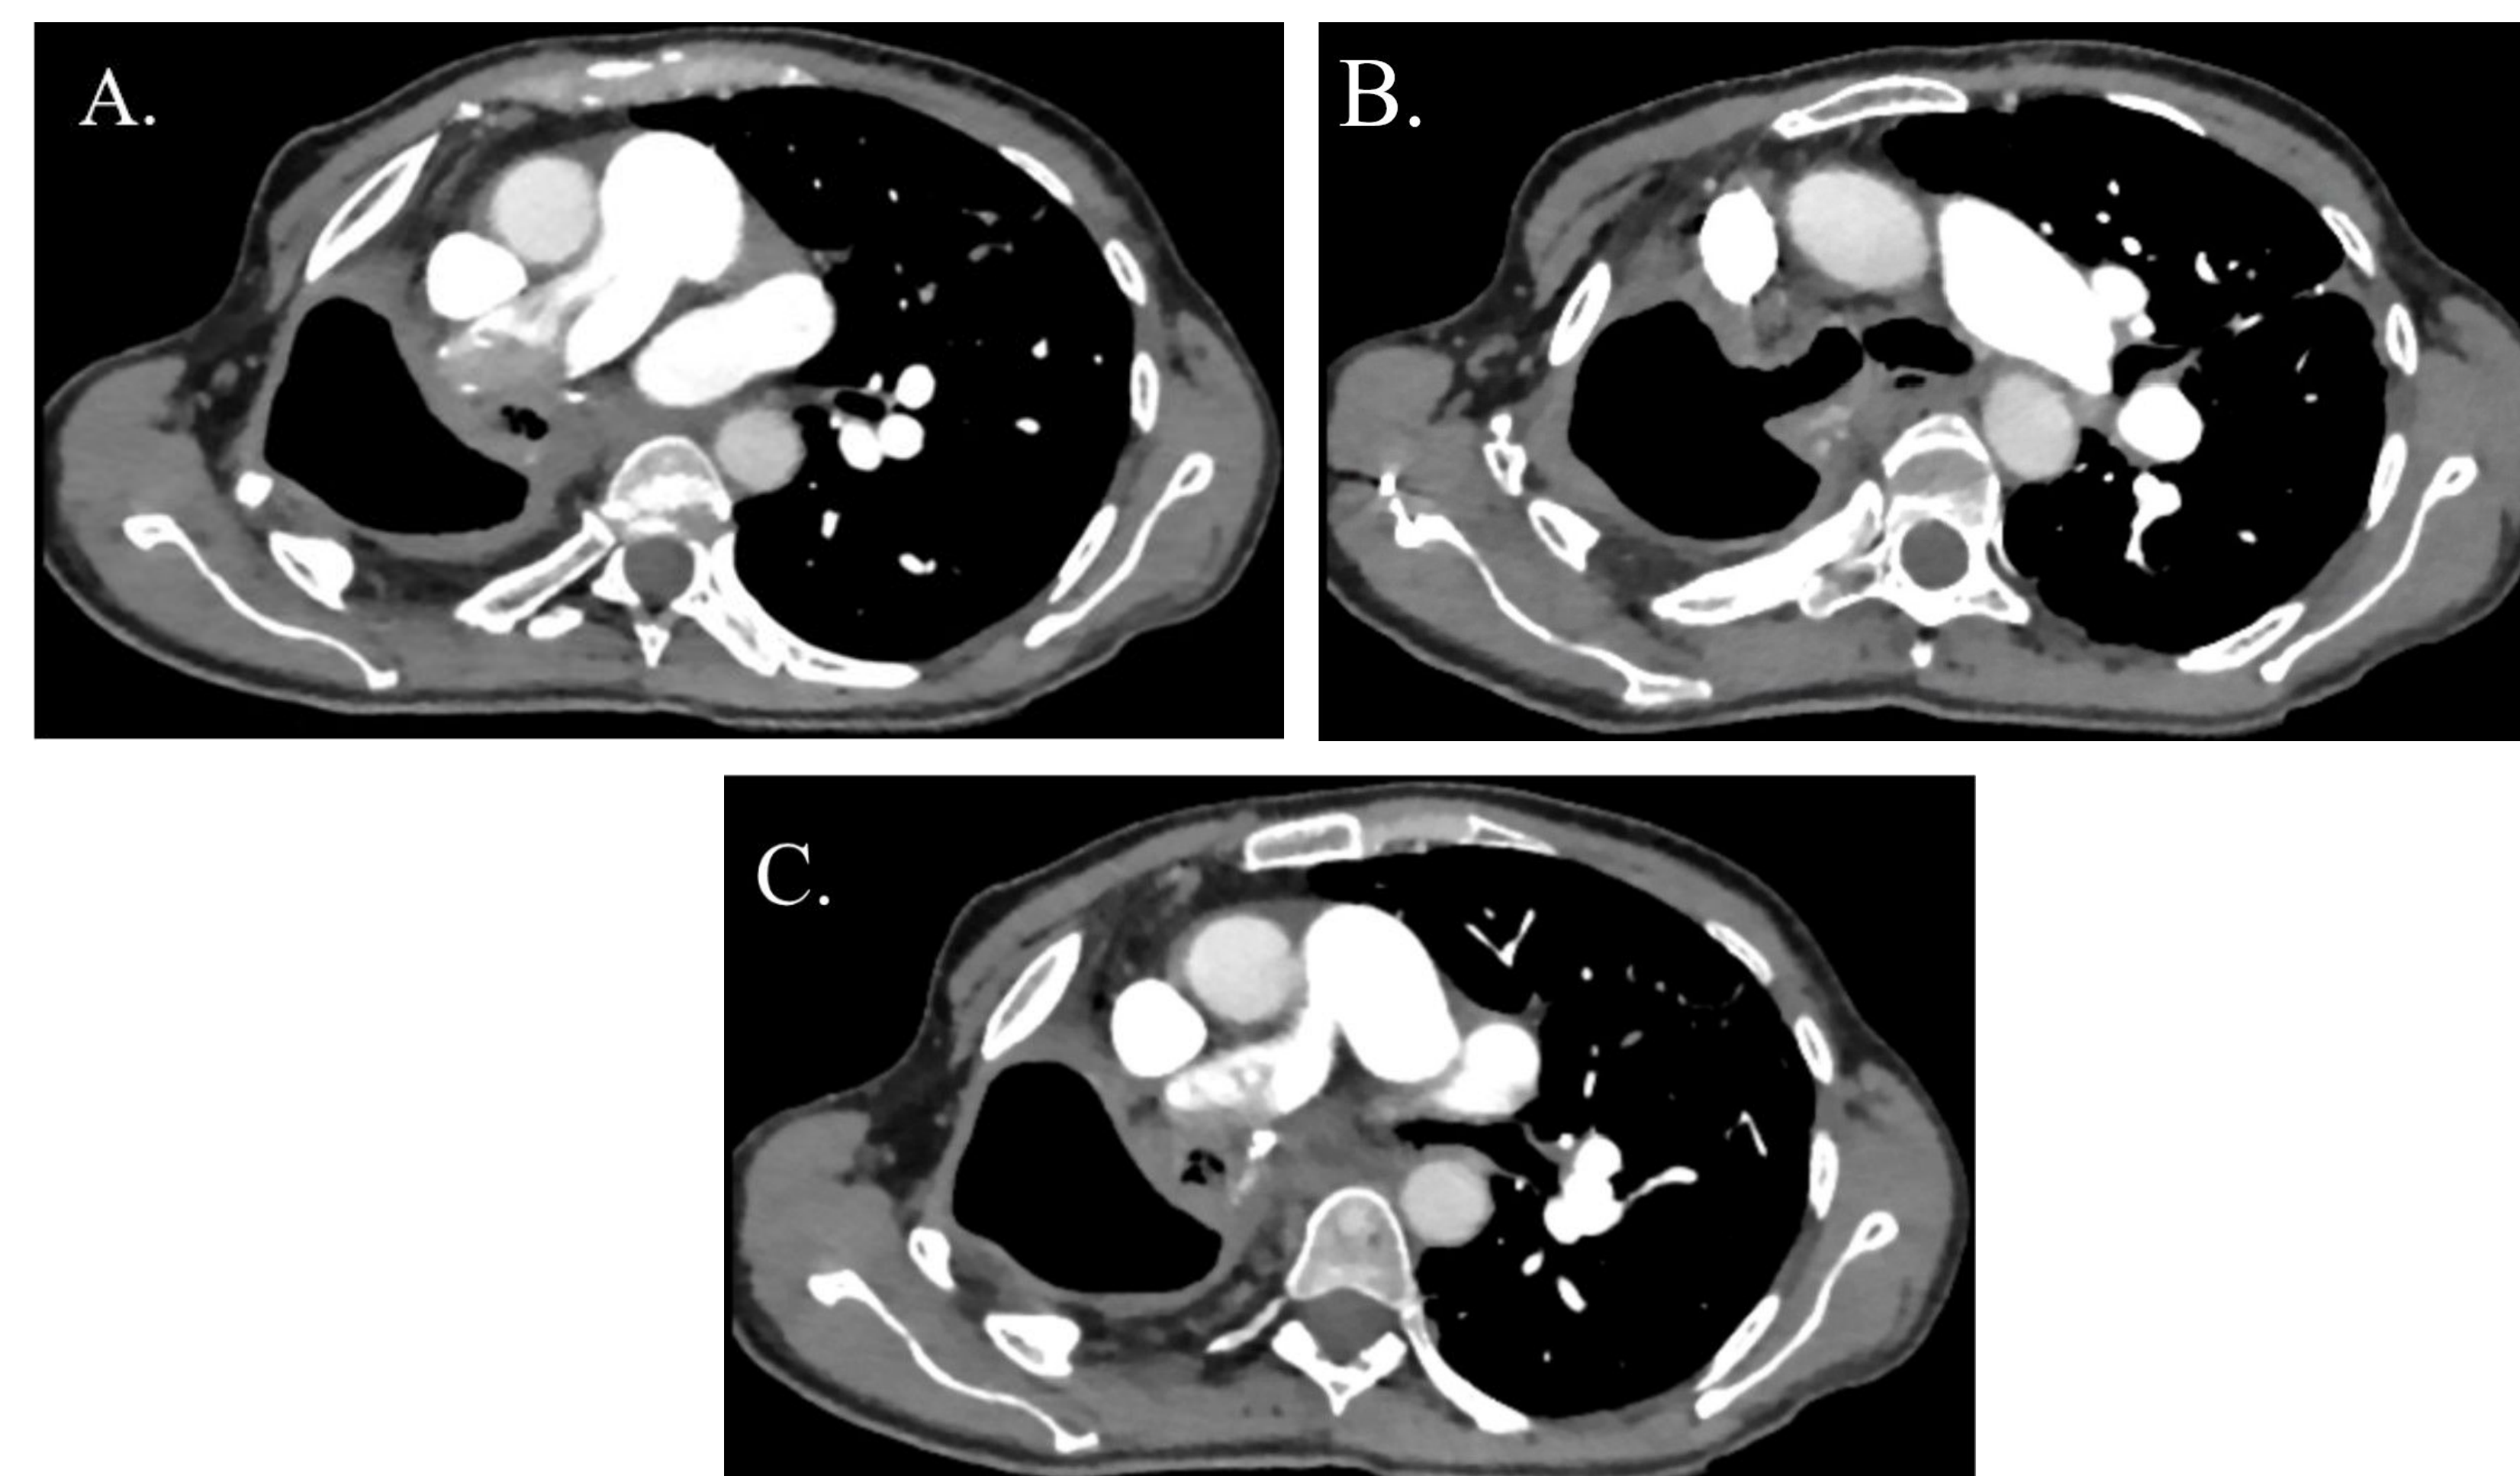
CT Pulmonary Embolism (axial slices). A. There is a large occlusive thrombus in the right main pulmonary artery with non-opacification of the intraparenchymal pulmonary arteries in the right lung. B. There is a bronchopleural fistula extending from the right main bronchus into the pleural cavity with collapse of the right lower lobe. C. There are peribronchial vascular nodular opacities in the left lung, associated with atelectasis.
